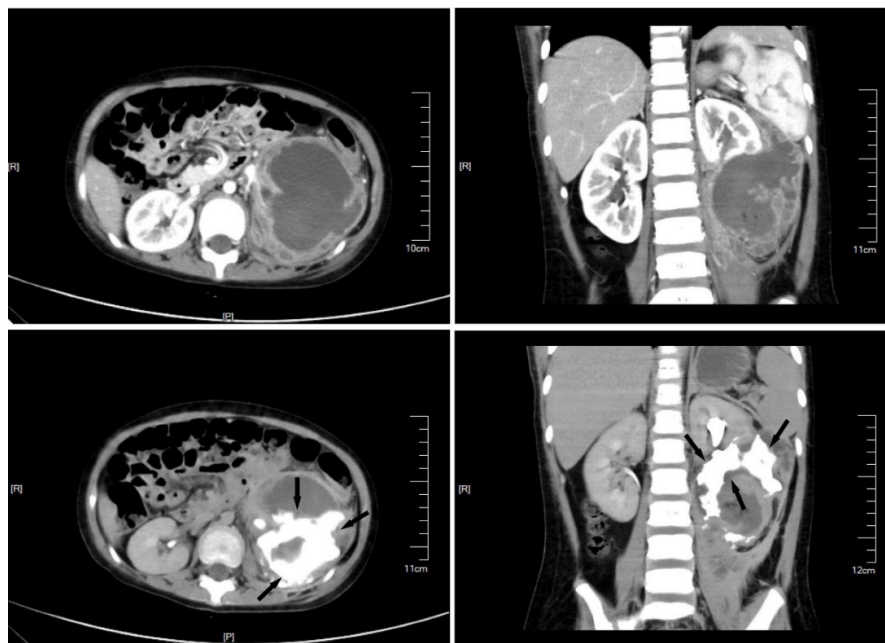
The kidney CT scan before ultrasound-guided interventional therapy. Massive perirenal fluid was found, and renal hilum and lower pole were compressed. The arrow indicates contrast agents found in the perirenal fluid.
